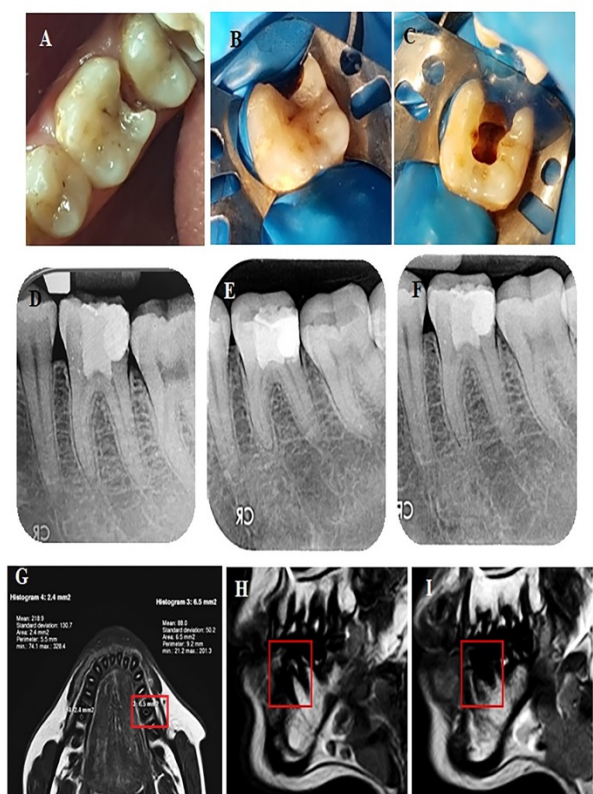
Showing the clinical, radiographic, & MRI assessment for the case no. 3. (A&B) showing pre-operative clinical photos of tooth #36 with extensive distal caries. (C) clinical photo of tooth #36 after pulpotomy & control of bleeding; (D-F) periapical radiographs taken immediate post-operative, after 6 months, & after 8 months of follow up respectively; (G-I) MRI at 6 month follow up showing in (G) axial slice comparing the mean signal intensity of the radicular pulp space of the pulpotomized tooth (#36) as compared to that of the contralateral normal radicular pulp; (H&I) Sagittal slices in the normal contralateral tooth in (H) & pulpotomized tooth in (I). Note the lack of signal in the pulpotomized tooth at 6 months follow up indicating pulp necrosis.
